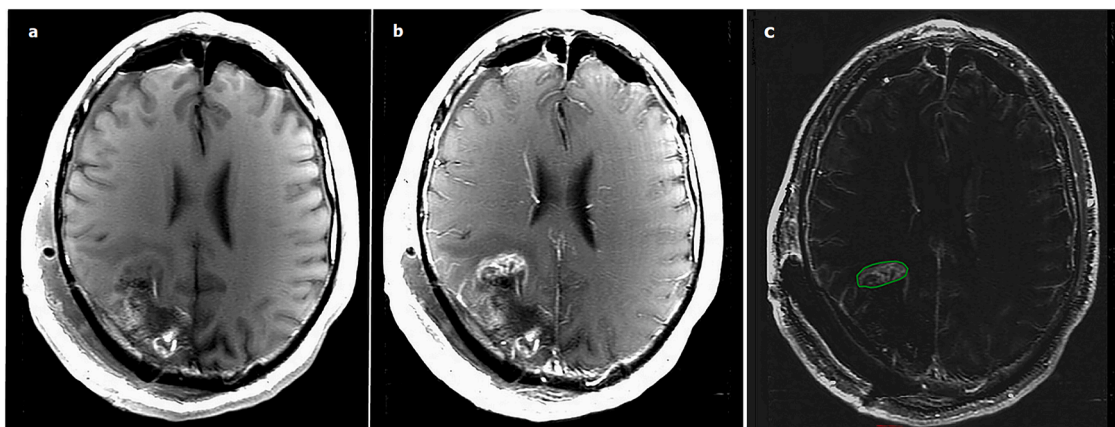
Right posterior glioblastoma in a 62-year-old man. a) Postoperative high-resolution 2D T1-weighted FSE axial image. b) Postoperative high-resolution 2D contrast-enhanced T1-weighted FSE axial image. c) Subtraction image with contrast-enhancing area manually delineated from neuroradiologist (green line).
